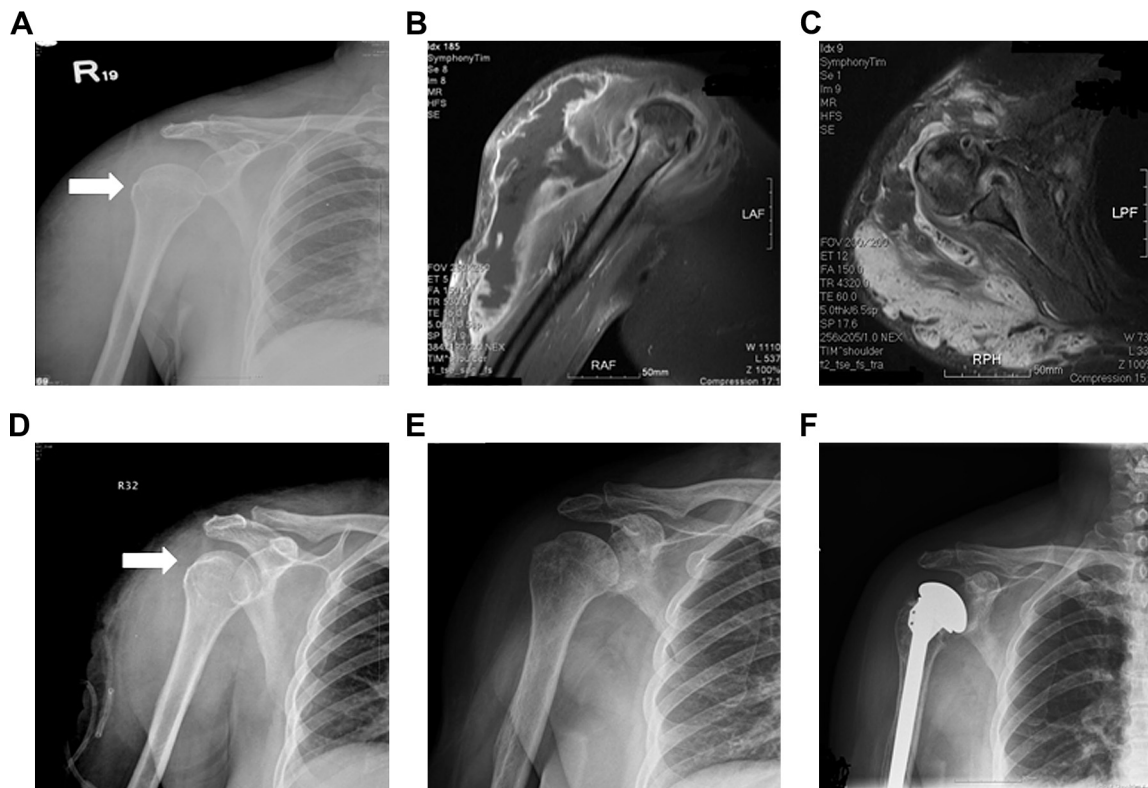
Case 1. The 55-year-old female suffered from right shoulder septic arthritis following acupuncture. (A) Anteroposterior radiograph shows right shoulder subluxation (white arrow); (B) T1 coronal magnetic resonance imaging (MRI) view; (C) T2 cross MRI view shows huge soft tissue abscess formation; (D) postoperative anteroposterior radiography reveals spontaneous reduction of subluxation (white arrow); (E) anteroposterior radiograph taken 1 year after the episode. The glenohumeral joint shows sclerotic changes with subchondral cyst formation; and (F) anteroposterior radiograph of the right shoulder. The patient underwent shoulder hemi-arthroplasty 16 months later.
